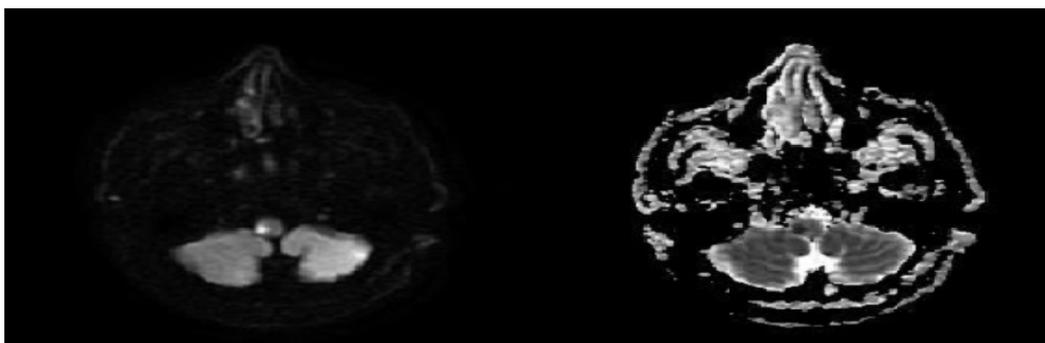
Cerebral magnetic resonance imaging (MRI) revealing hyperintensity on diffusion sections and hipointensity in apparent diffusion co-efficient sections of the right posterolateral area of the bulbus. These findings were considered to be consistent with acute ischemia.
